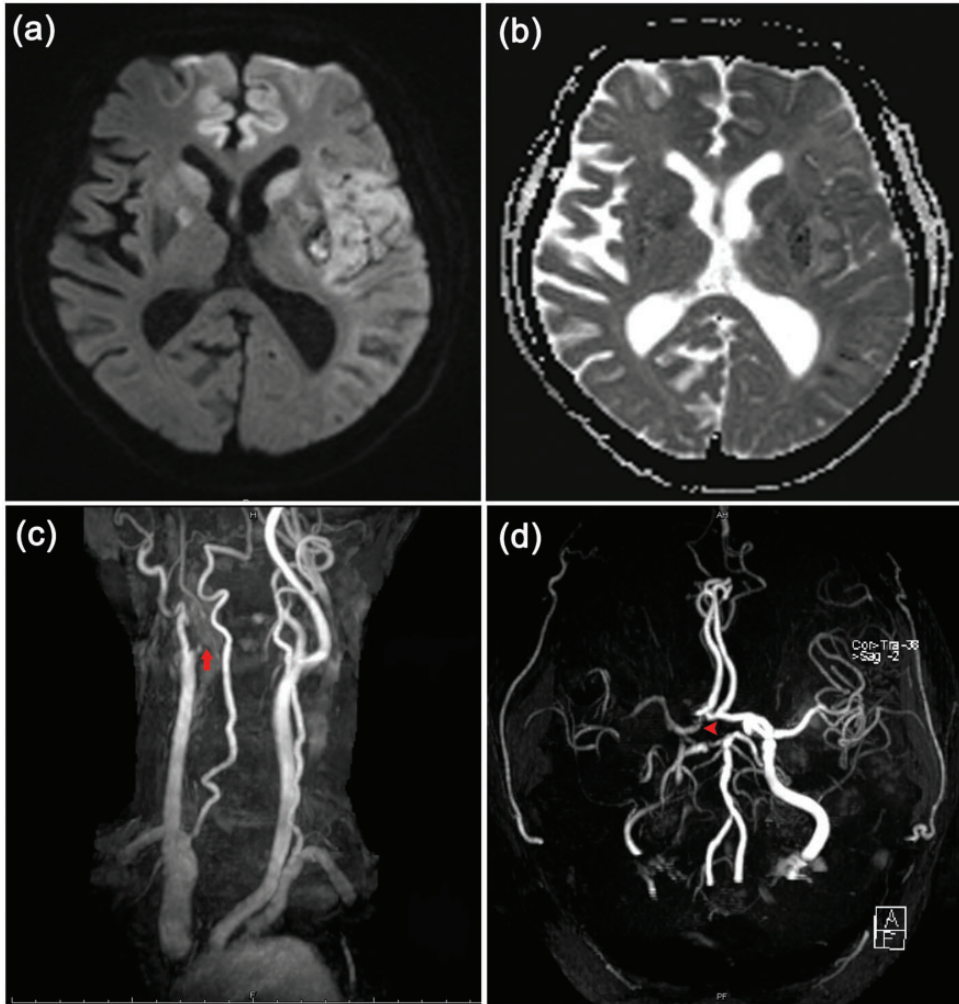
(a) Brain magnetic resonance imaging revealed increased signal intensities in the bilateral anterior cerebral artery (ACA) territory and left middle cerebral artery (MCA) territory on diffusion-weighted imaging. (b) Brain magnetic resonance imaging demonstrated decreased signal intensities in the bilateral ACA territory and left MCA territory on apparent diffusion coefficient-calculated images. (c) Neck magnetic resonance angiography demonstrated severe arteriosclerosis and almost complete occlusion at the initial part of the right internal carotid artery (arrow). (d) Head magnetic resonance angiography revealed severe arteriosclerosis at the C4 to C6 segment of the right internal carotid artery, right MCA, and A1 segment of the right ACA (arrowhead).
